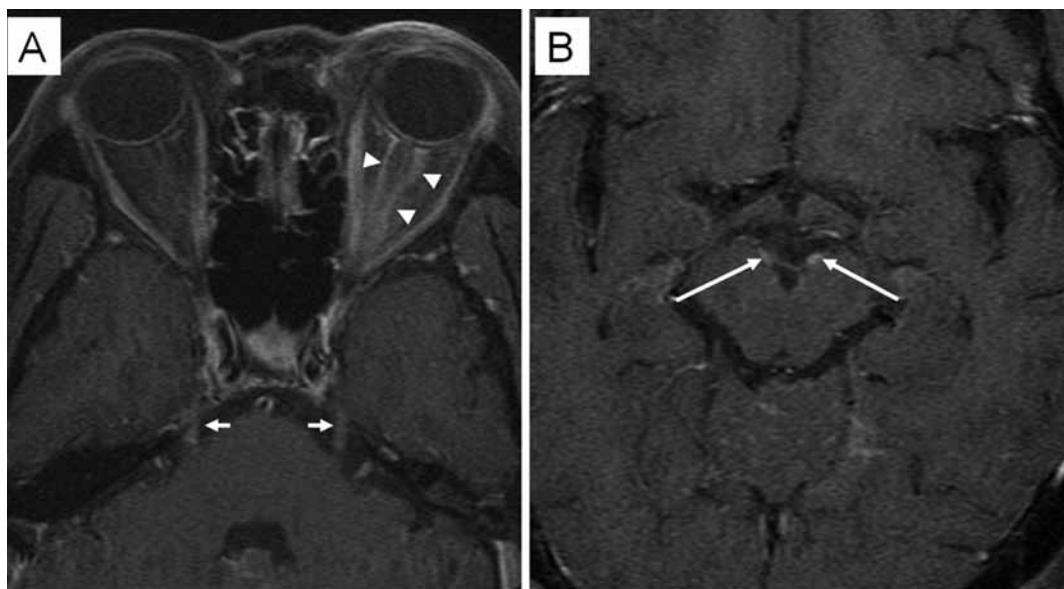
Axial brain MRI with contrast showing enhancement of left optic nerve (arrowheads), bilateral trigeminal nerves (short arrows) (2A) and bilateral oculomotor nerves (long arrows) (2B).
